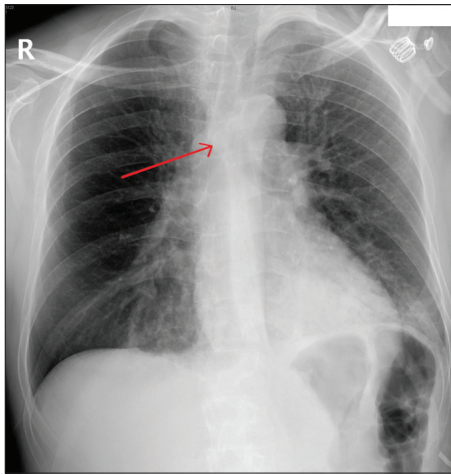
Chest X-ray showing lobulated lesion at the level of the carina (red arrow)
